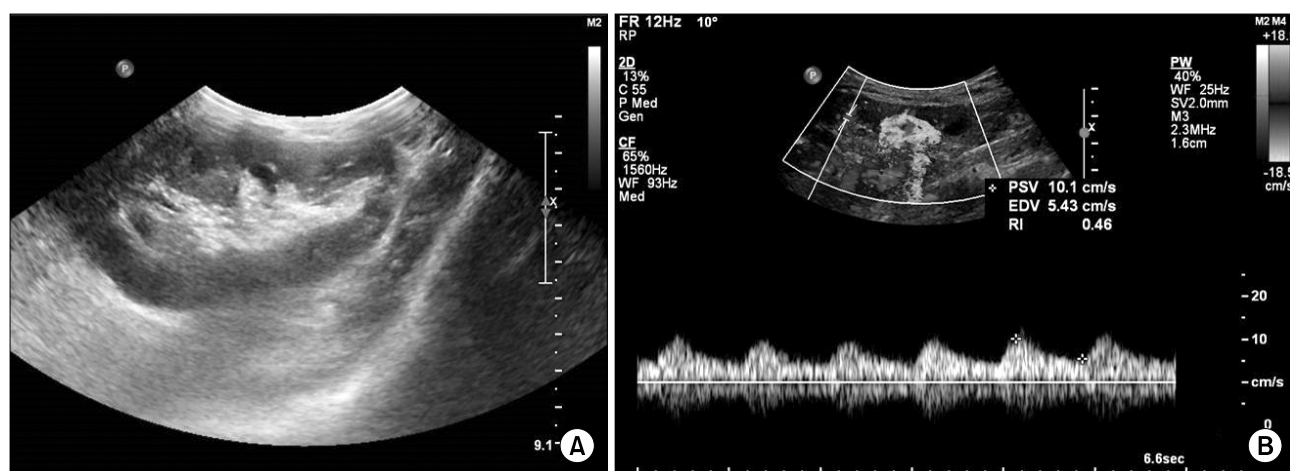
Color Doppler ultrasonography showing (A) normal size and echogenicity of the transplant kidney and (B) low resistive index and pulsus parvus et tardus of flow pattern in the intrarenal artery: stenosis proximal to the transplant renal artery.
